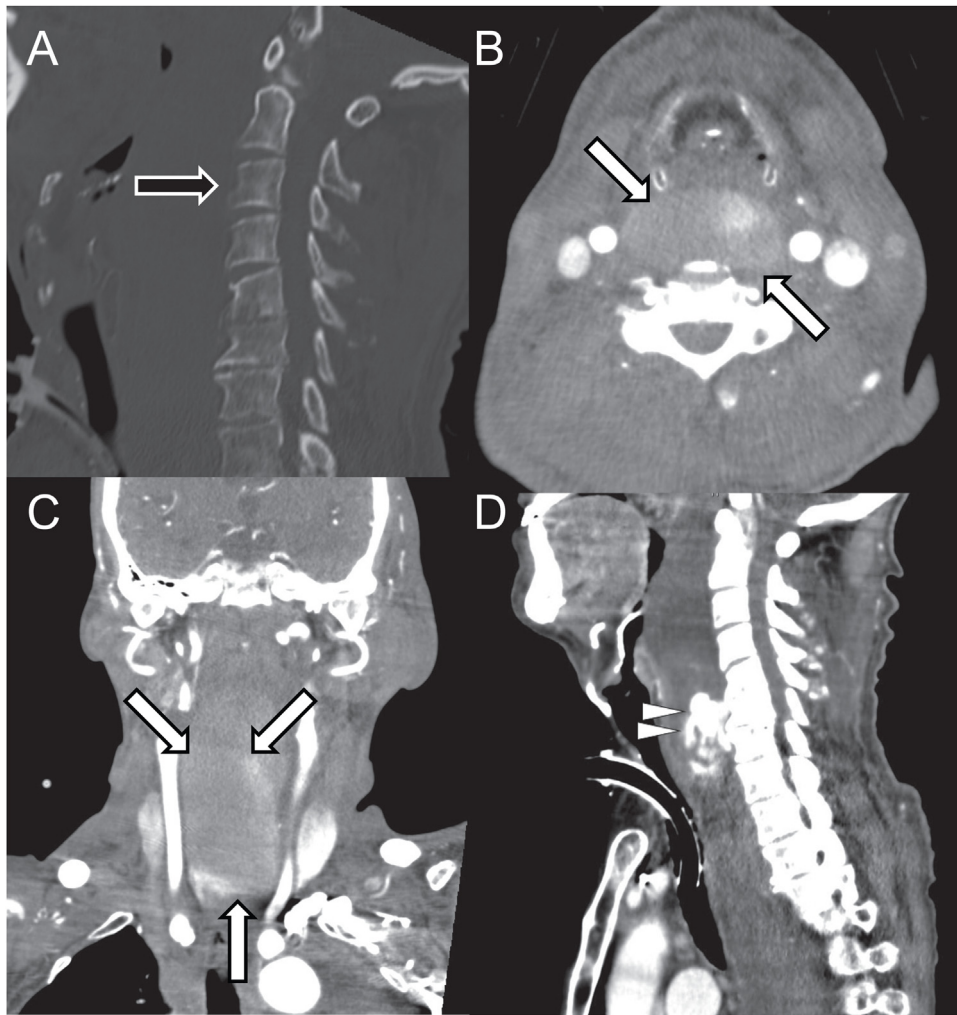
Contrast-enhanced computed tomography images of the neck. A widespread hematoma and anterior airway displacement were observed in the retropharynx with leakage of the contrast medium in coronal (A), sagittal (B), and transverse (D) plane. The arrows indicate the leakage of the contrast medium. Cervical fracture was also noted (C).
